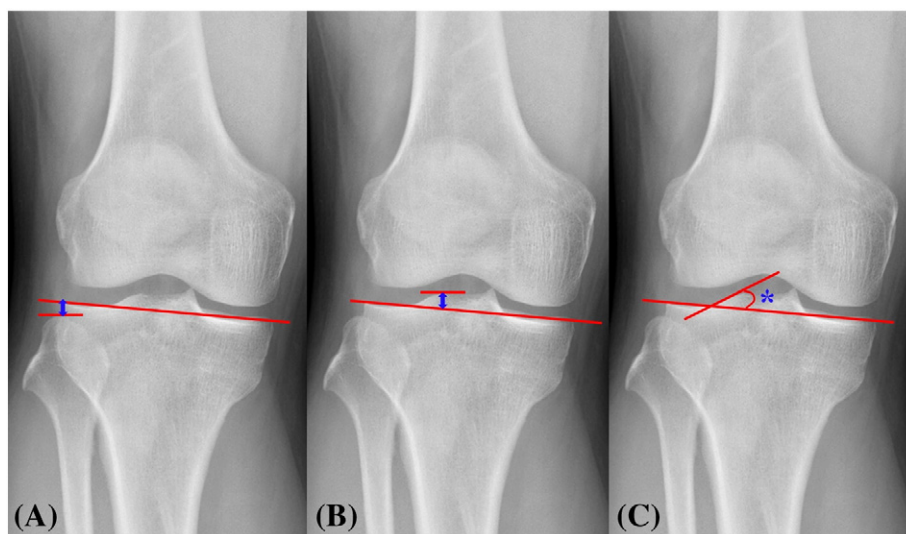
The radiographic assessments on weight-bearing anteroposterior view. (A) Fibular height, (B) height of lateral tibial spine and (C) obliquity of lateral tibial spine.
